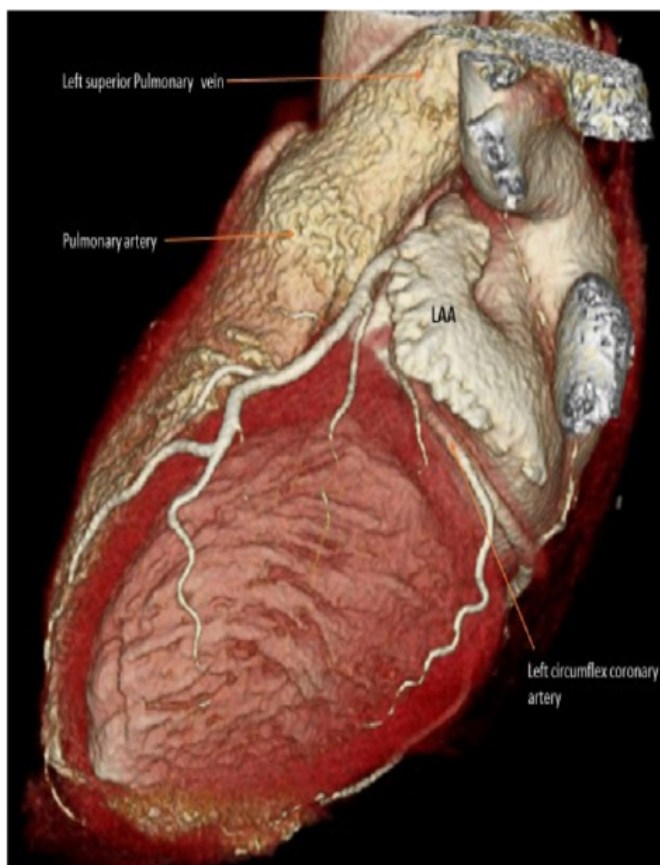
CT scan showing posteriorly directed LAA tucked underneath the pulmonary artery
